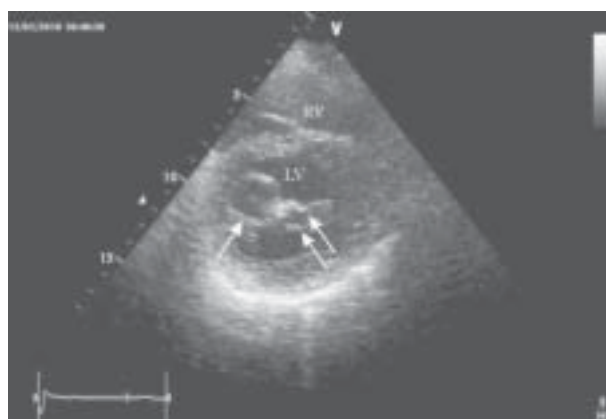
Short-axis transthoracic view. Complete bridge type of double-orifice mitral valve. The orifices (arrows) unequal in size; RV — right ventricle; LV — left ventricle
